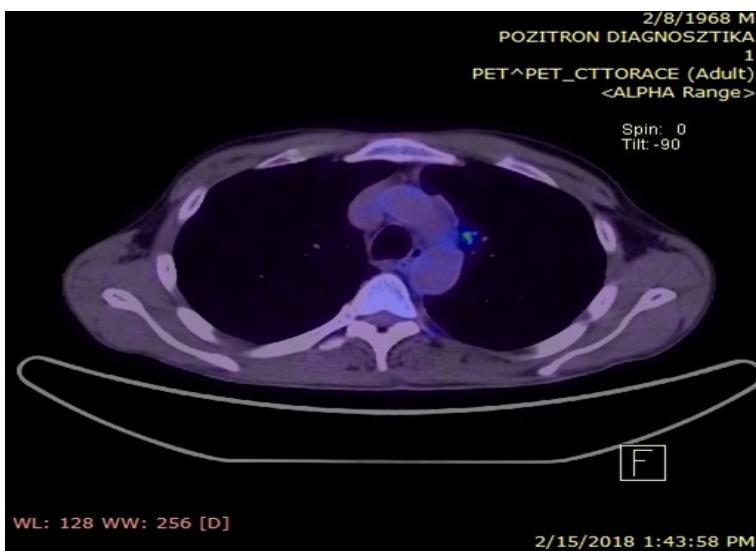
PET-CT (15.02.2018): Complete Response
